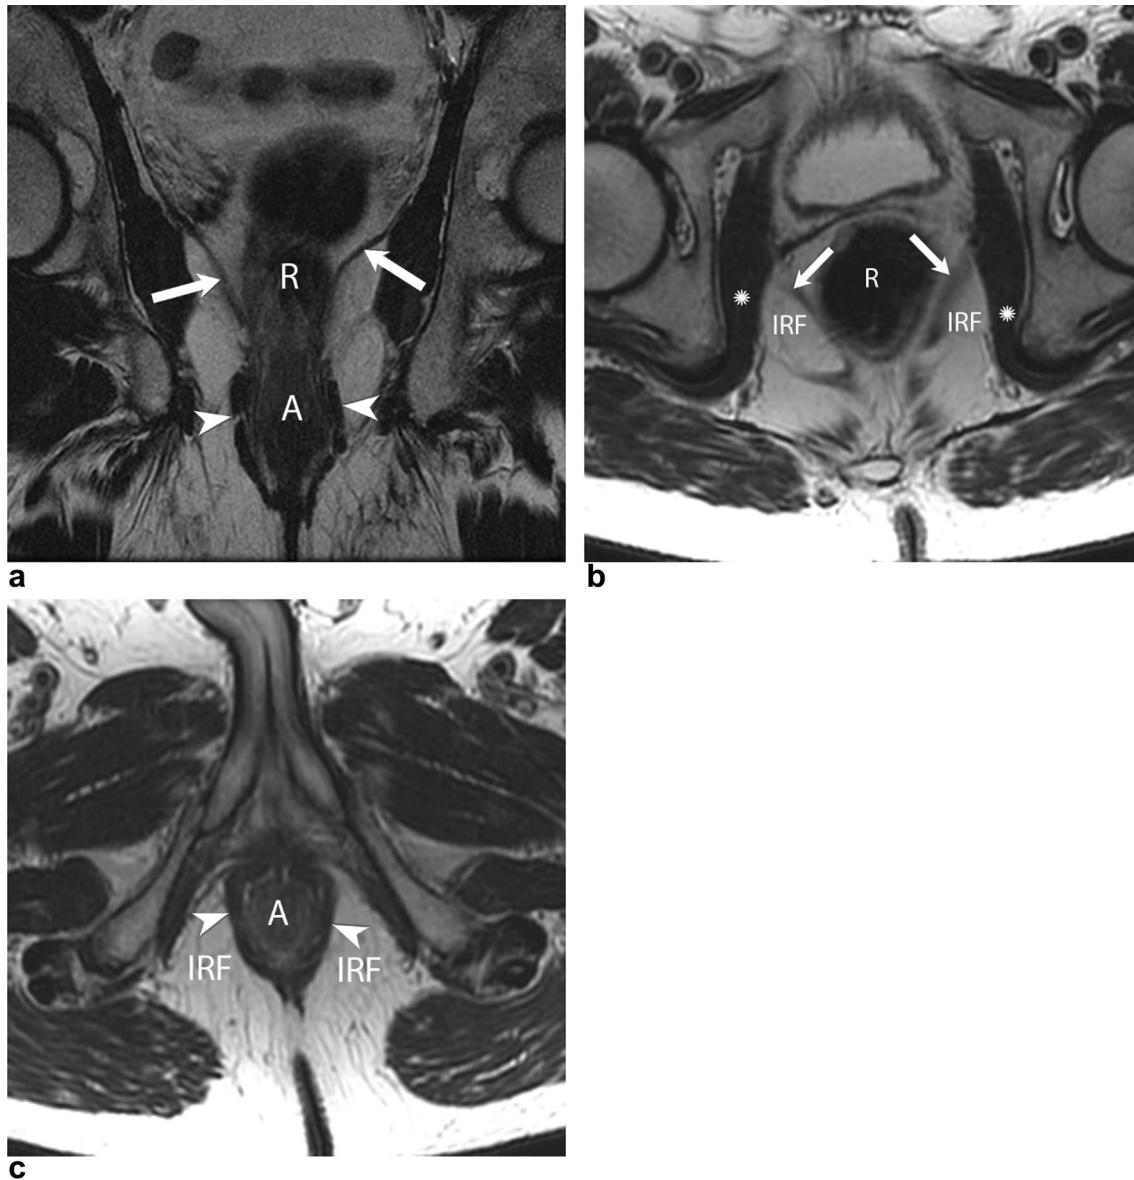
Ischioanal fossa anatomy. MRI pelvic images depicting the anatomical location and boundaries of the ischioanal fossa. a Coronal T2WI shows the levator ani muscle (white arrows) that forms the superior border of the ischioanal fossa and the external anal sphincter (white arrowheads) that limits its medial borders. b Axial T2WI
